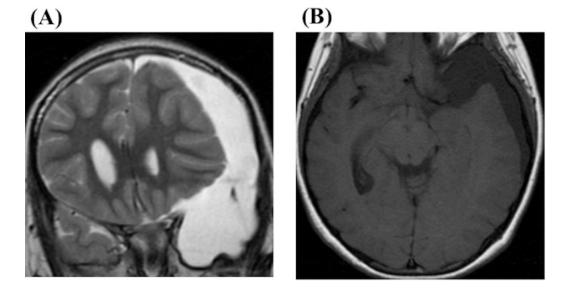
A 9-year-old girl suffered with a headache, nausea, and diplopia showed an arachnoid cyst in the left-side middle fossa and ipsilateral CSDH with a remarkable mass effect on MRI (A; coronal section on T2WI, B; axial section on T1WI). Irrigation of the CSDH, partial removal of the outer membrane of the cyst and CSDH, and endoscopic cystocisternostomy were performed to relieve her symptoms. Postoperative clinical course was excellent.
